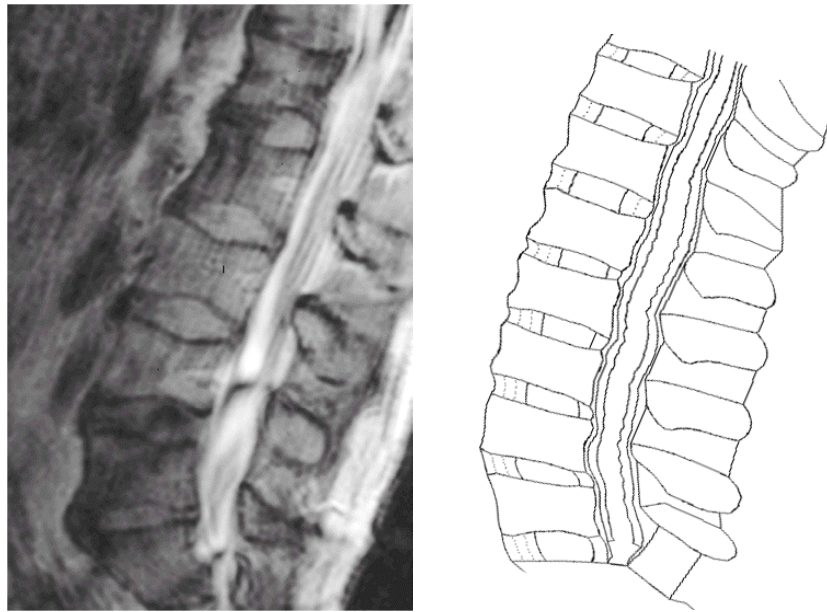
Lumbar spine position as measured using an Upright MRI, and the positioned THUMS 5 lumbar spine.
